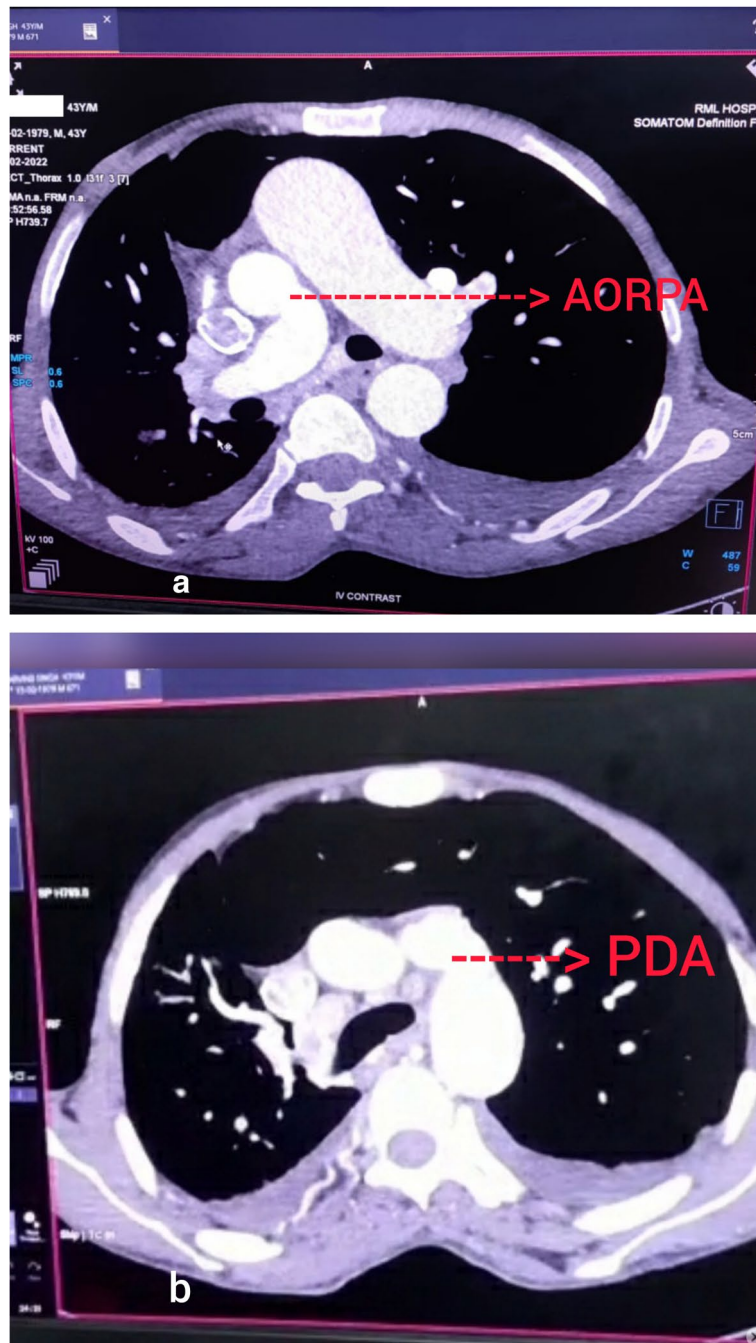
CT cardiac with pulmonary angiogram. a AORPA b PDA
